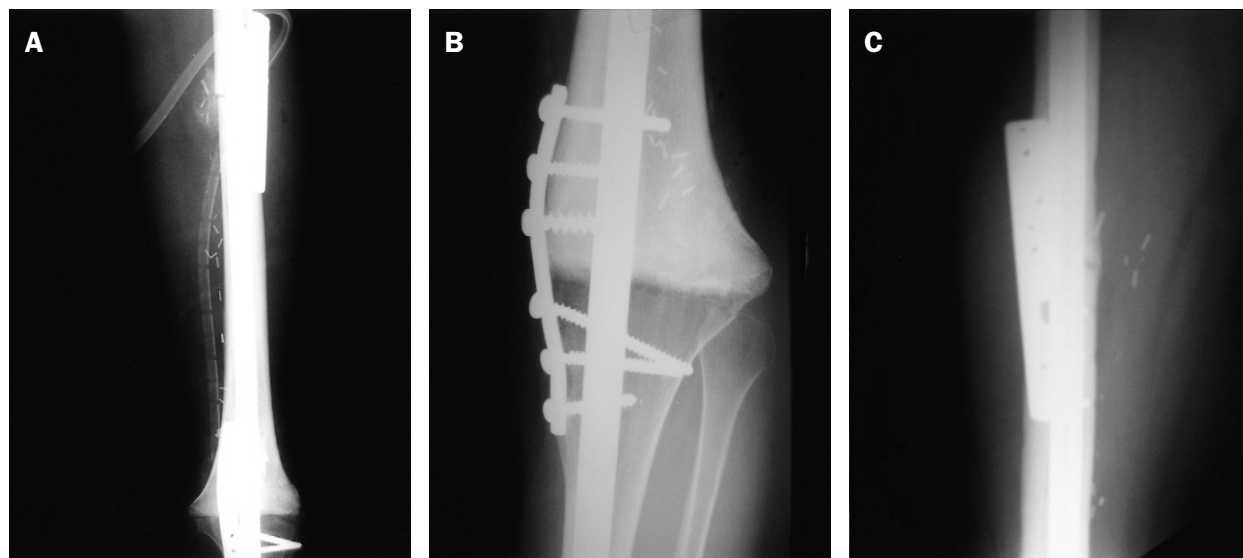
A 13-year-old girl with distal femur osteosarcoma of the left leg: (A) immediate postoperative X-ray; (B) solid union over the metaphyseal junction was achieved 16 weeks postoperatively; (C) solid union over the diaphyseal junction was achieved 26 weeks postoperatively.
